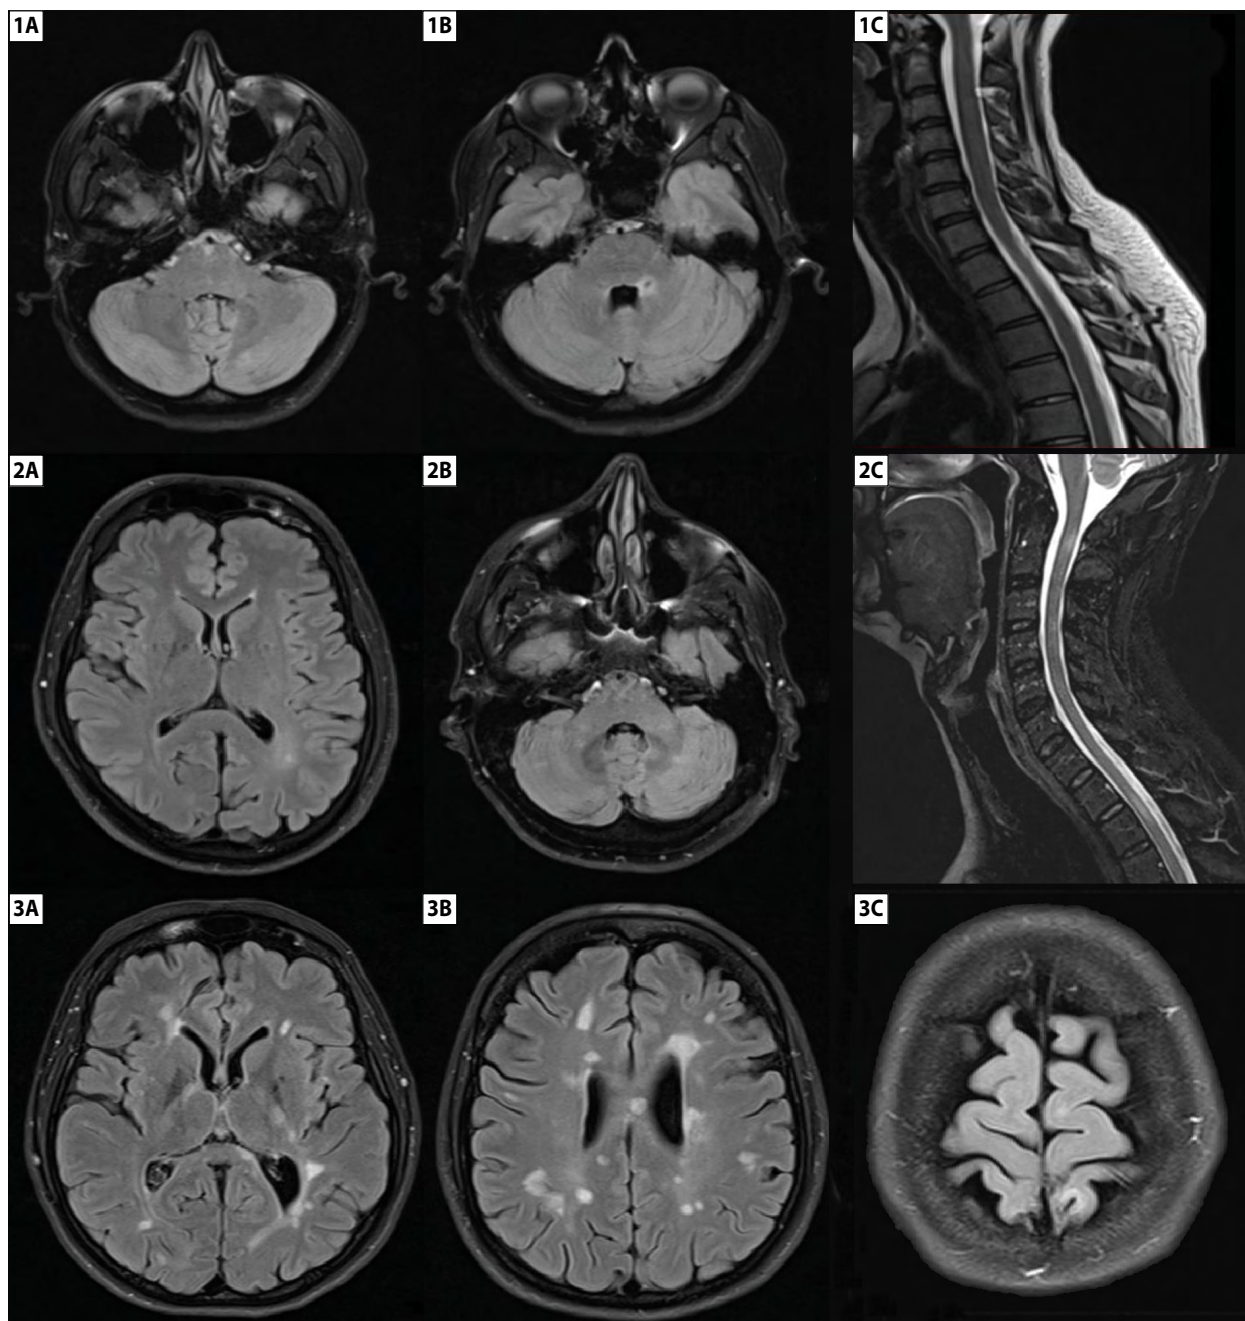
Case 1 (1A–1C): FLAIR-T2 hyperintense demyelinating lesions periventricularly in pons and cerebellum (1A–1B); no lesions in cervical and thoracic spinal cord (1C). Case 2 (2A–2C): multiple FLAIR-T2 hyperintense lesions supratentorially in cerebellum and cervical spinal cord (T2). Case 3 (3A–3C): multiple FLAIR-T2 hyperintense lesions periventricularly (3A–3B) and juxtacortically (3C)
